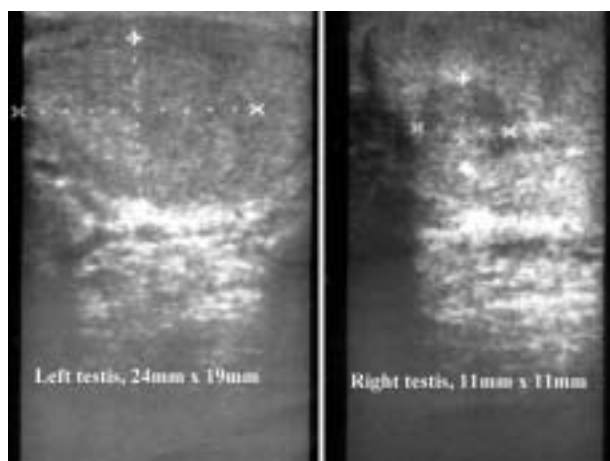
Scrotal ultrasonography showing a 2.4 cm x 1.9 cm mosaic mass in the left testis (left panel) and a 1.1 cm x 1.1 cm hypoechoic mass in the right testis (right panel).
